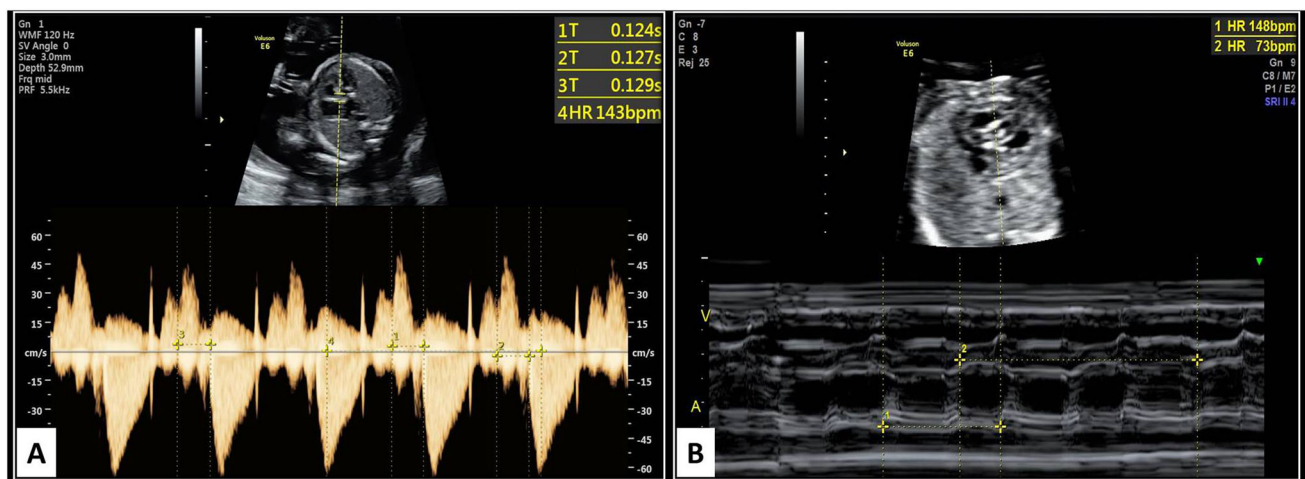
Spectral Doppler image for case no. 7 showing a Normal PR interval and normal FHR at 20 weeks gestation. b At 23 weeks gestation, fetus developed A-V block with a ventricular heart rate of 64–76 bpm
